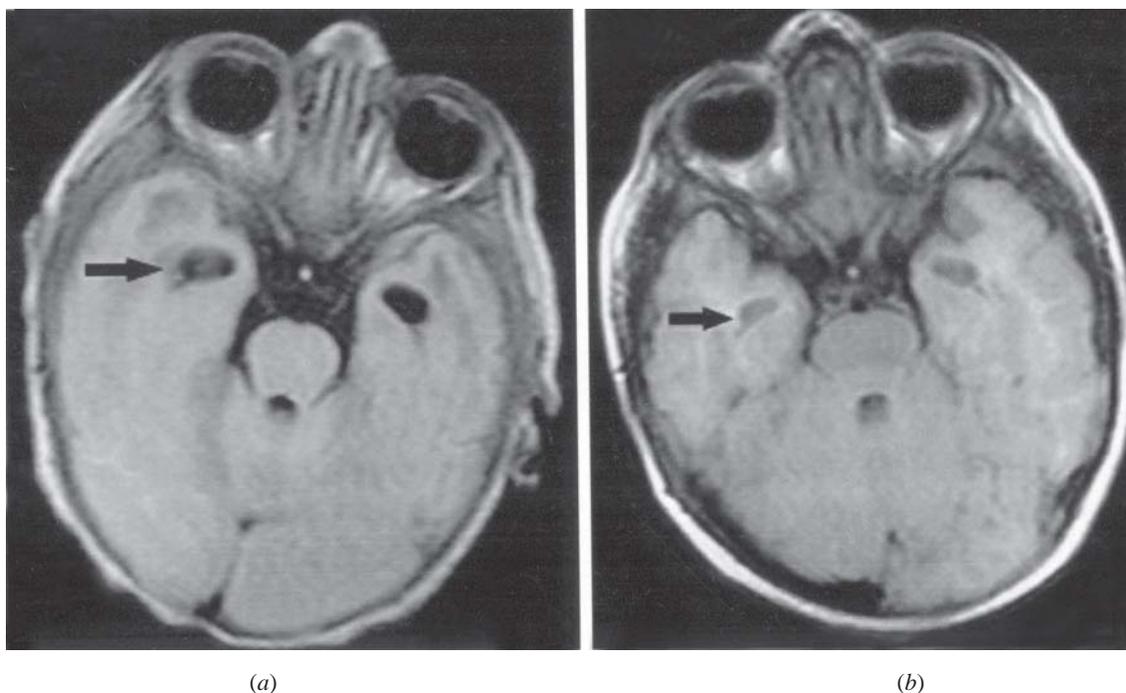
(a) MRI findings (FLAIR image axial section) on day 15 showing symmetrical cystic lesions in the anterior temporal white matter (arrow), (b) Follow up scan after 9 months (FLAIR image axial section) shows persistence of cystic lesions in the anterior temporal white matter (arrow).
